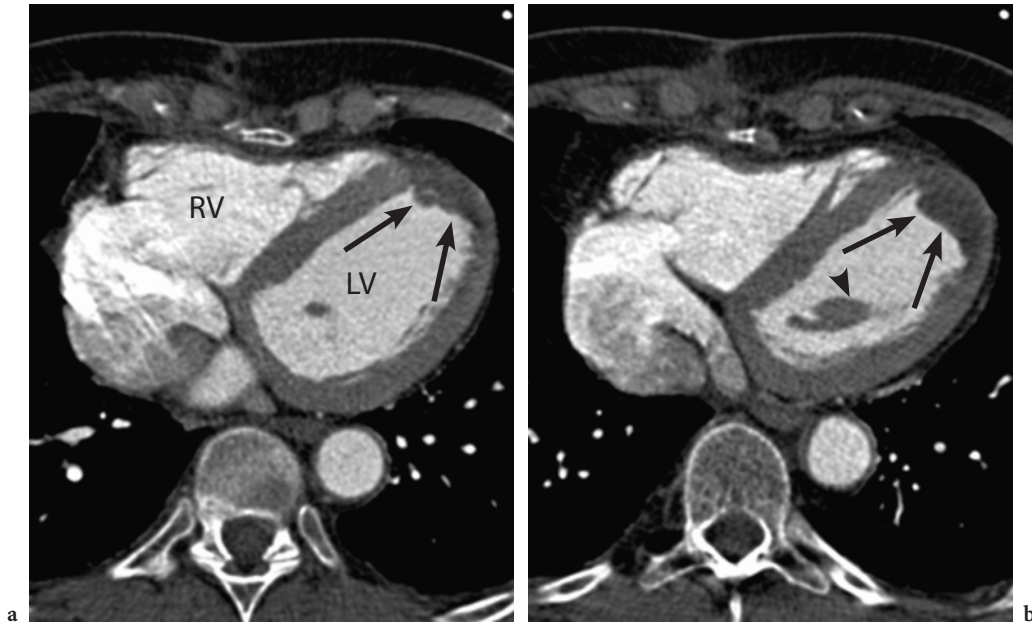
Cardiac 16-slice CT examination of a patient after myocardial infarction. The ventricular anatomy is displayed in two axial levels (a, b). At the apex, a crescent-shaped low-density rim consistent with a ventricular thrombus (*arrows*) can be identified. The intracavitary structure (*arrowhead*) represents the posterior papillary muscle
